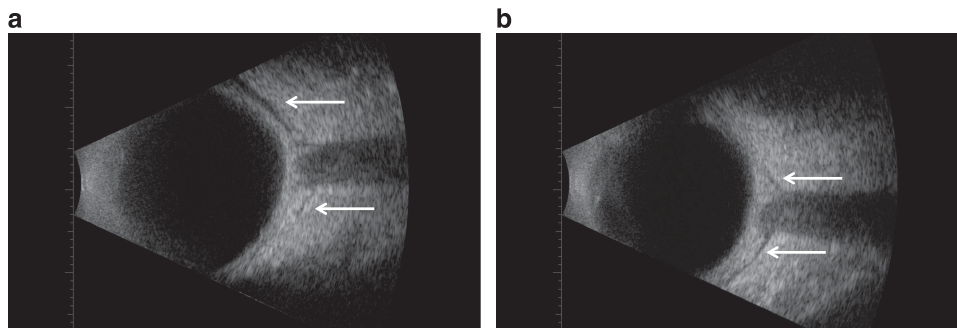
B-scan ultrasound images with arrows showing expanded posterior sub-Tenon space and 'T-sign' following (a) standard sub-Tenon technique and (b) incisionless sub-Tenon technique.
